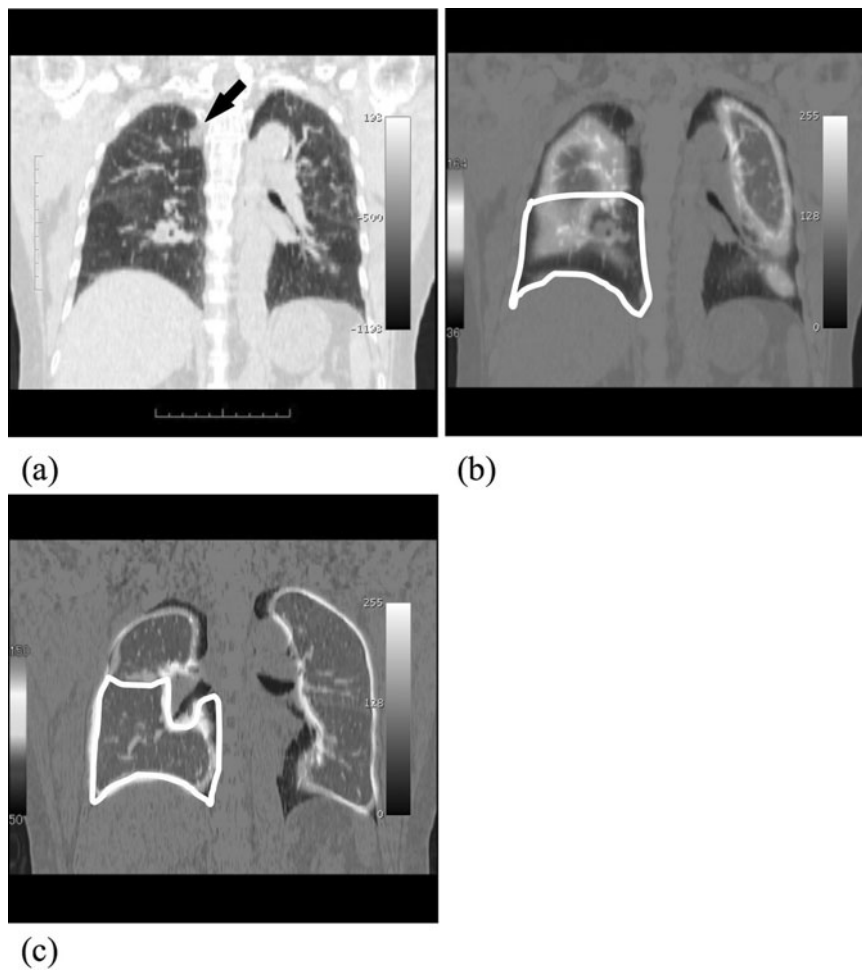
Segmentectomy case. a Coronal CT image before surgery, showing a tumor in the right upper lobe. b Perfusion SPECT/CT before surgery. The image of the right middle lobe is surrounded by a solid line. The FEV_1 of the right middle lobe was 0.30l. c Perfusion SPECT/CT after a segmentectomy of the right upper lobe. The image of the right middle lobe is surrounded by a solid line. The FEV_1 of the right middle lobe was changed to 0.24l
